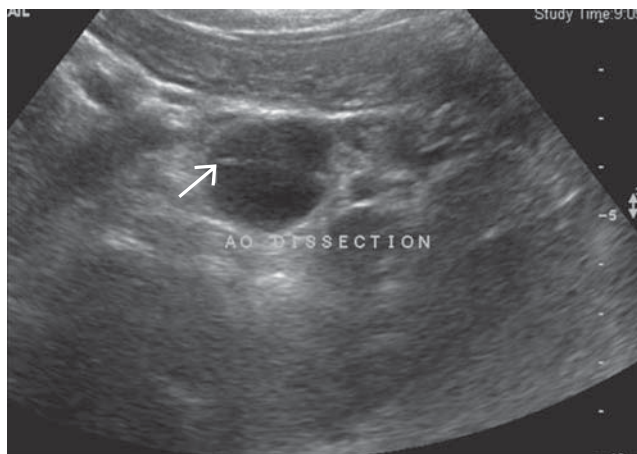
A 67-year-old male with sudden-onset back pain underwent duplex ultrasonography. The initial sonogram demonstrated a flap within the lumen of the abdominal aorta consistent with a dissection flap (arrow).
